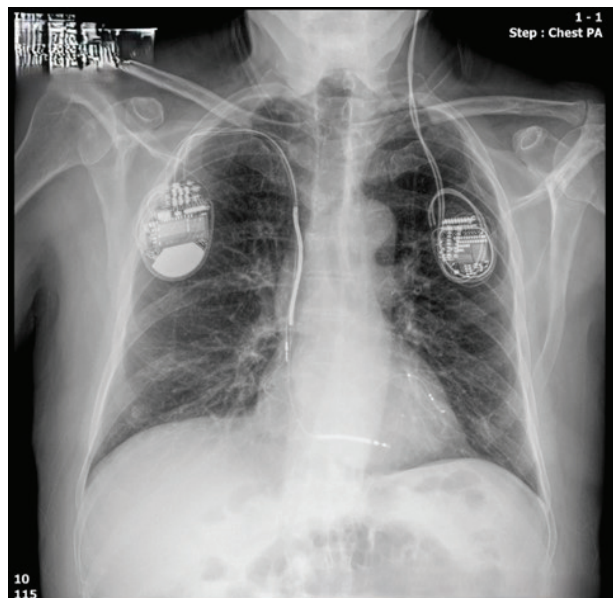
both pacemakers are seen on the chest X-ray.
